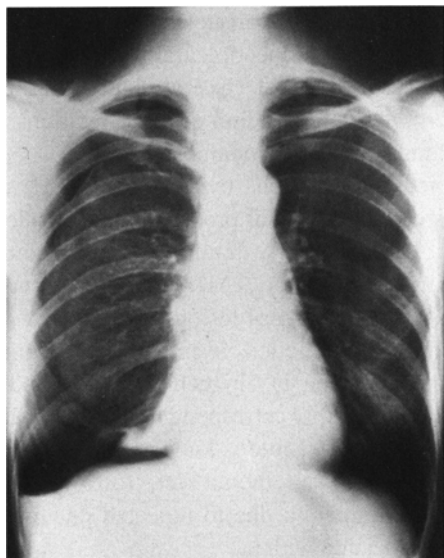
Chest X-ray film demonstrating right-sided pneumothorax with pleural effusion.
